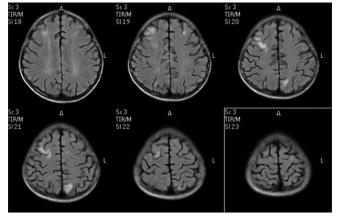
Repeat magnetic resonance imaging brain showing hyperintense signals on T2- and fluid-attenuated inversion recovery images
